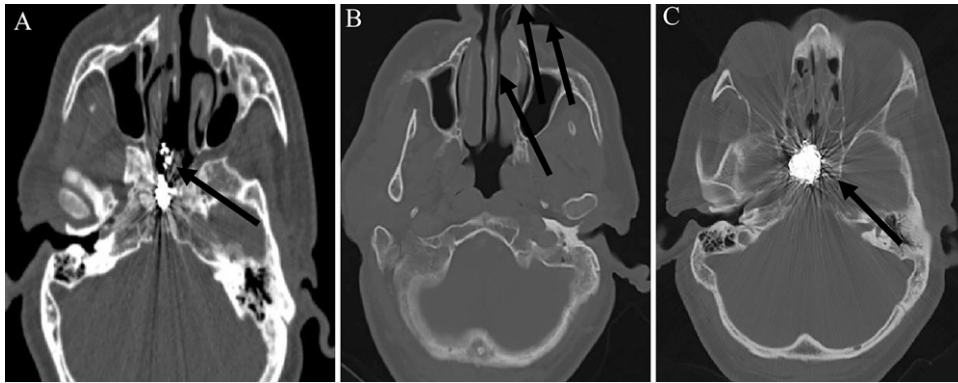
Preoperative CT scan demonstrating the aberrant coil (A and B). The coil material is seen protruding up to the outside of the nose (*arrows*). Cranial CT image after the second embolization application (C). The coil material has been cut to leave a piece of the sphenoid sinus roof. No coil material is noted along the arrow.
